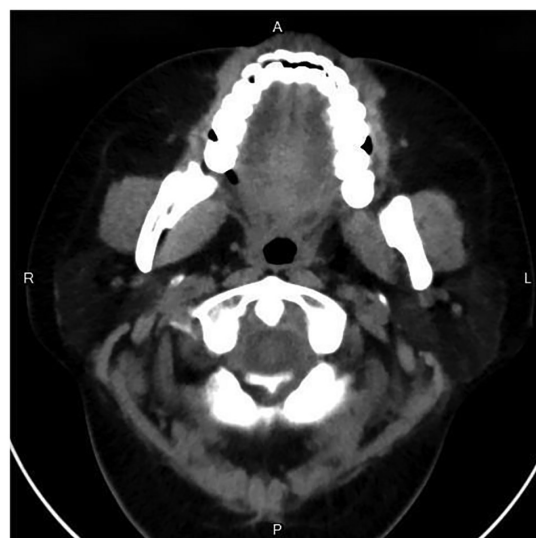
Computed tomography scan showing soft tissue recovery around the mandible after treatment. A, anterior; R, right; L, left; P, posterior.
